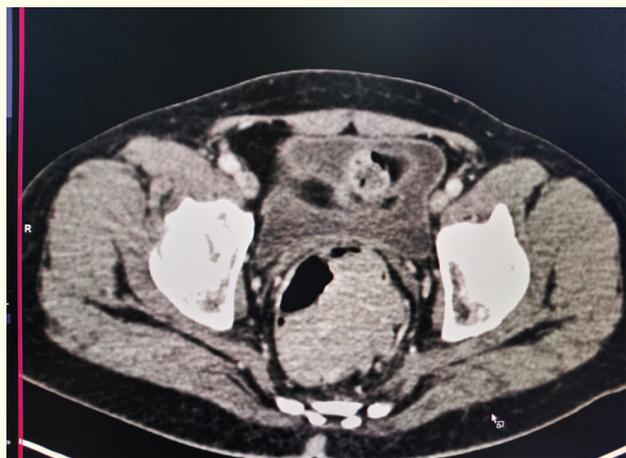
CT RECTAL MASS.
